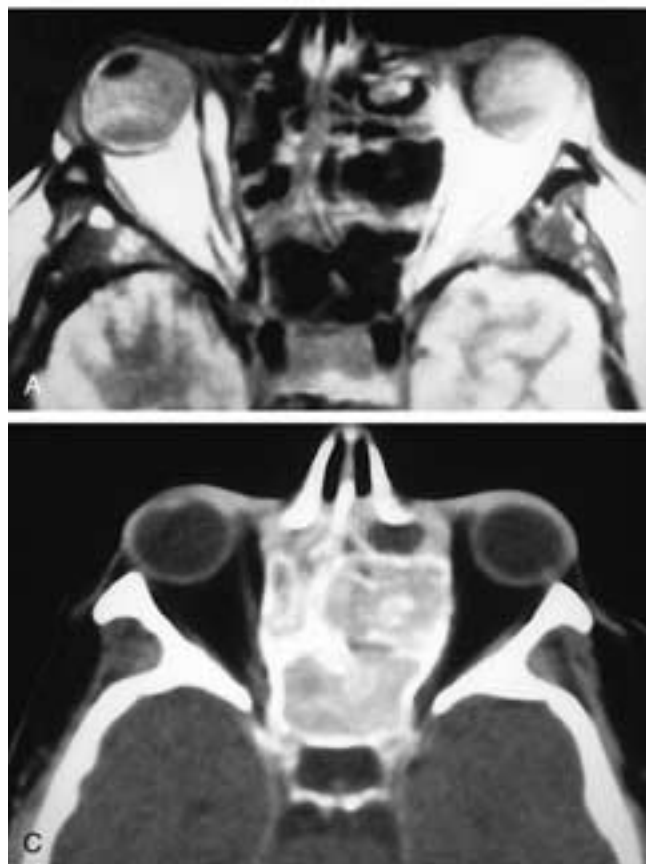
Axial T1-weighted (A) and T2-weighted (B) MR images show expansion of the ethmoid complexes, with apparently moderate mucosal thickening in the ethmoid sinuses. The sphenoid sinuses appear aerated. However, a CT scan (C) shows that the expanded ethmoid and sphenoid sinuses are totally opacified, with desiccated secretions. This patient had chronic sinusitis.
